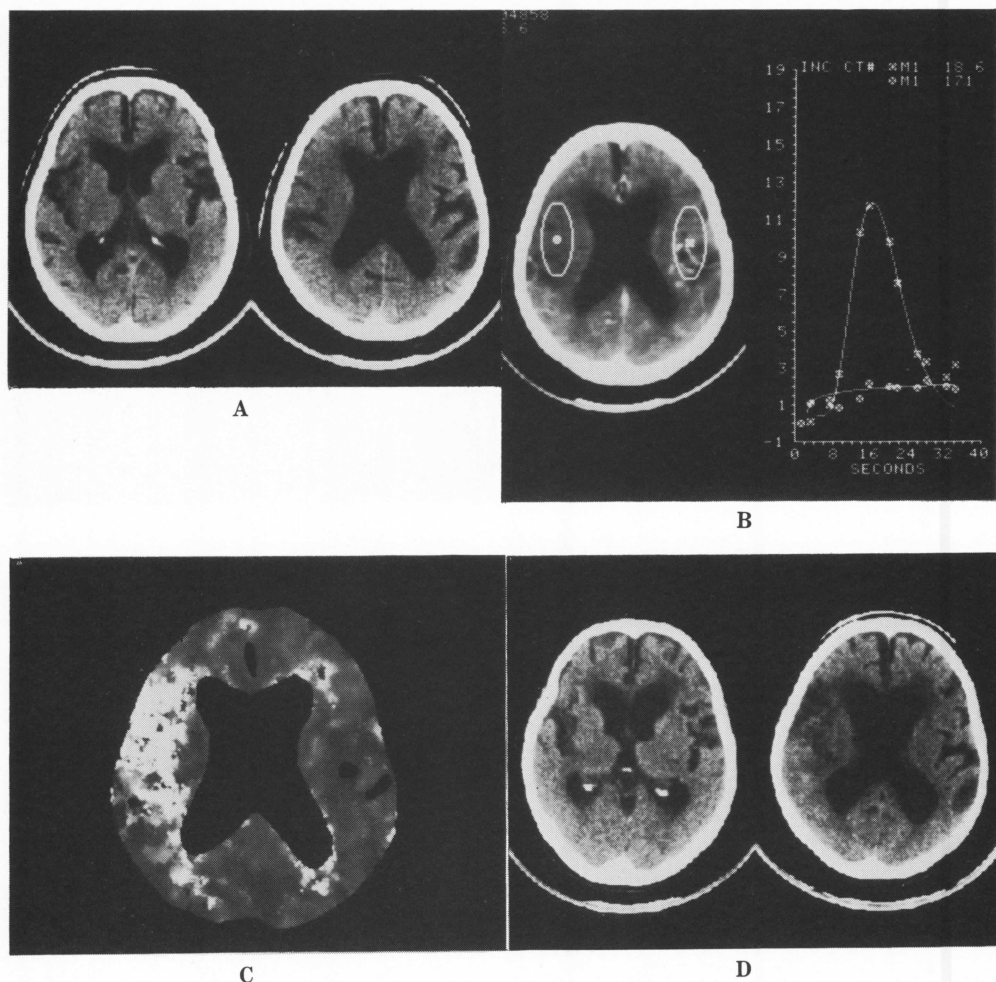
Case 1, 84-year-old woman with numbness and left hemiplegia. A: Conventional CT scans are equivocal, showing obscured sulci and decreased density in the right operculum. B: Analysis of time-density curves indicates no perfusion in the same area. C: The M1-functional image distinctively demonstrates the existence and the extent of impaired perfusion. D: CT scans performed four weeks later show dissolution of the right operculum.
